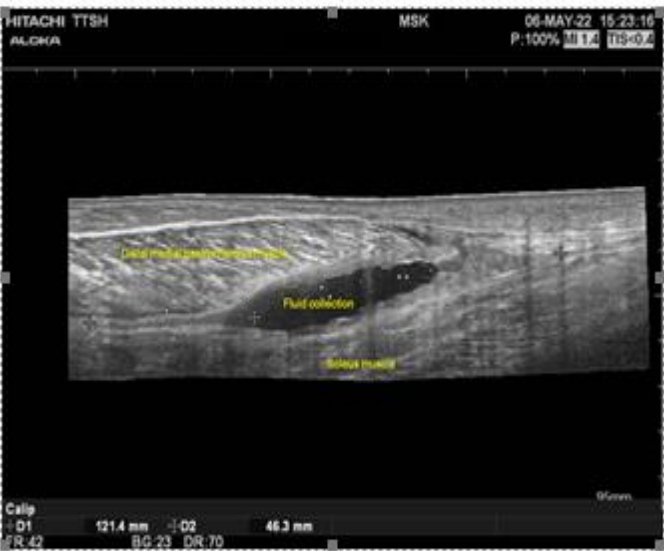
Ultrasound image of Patient A on initial consultation
